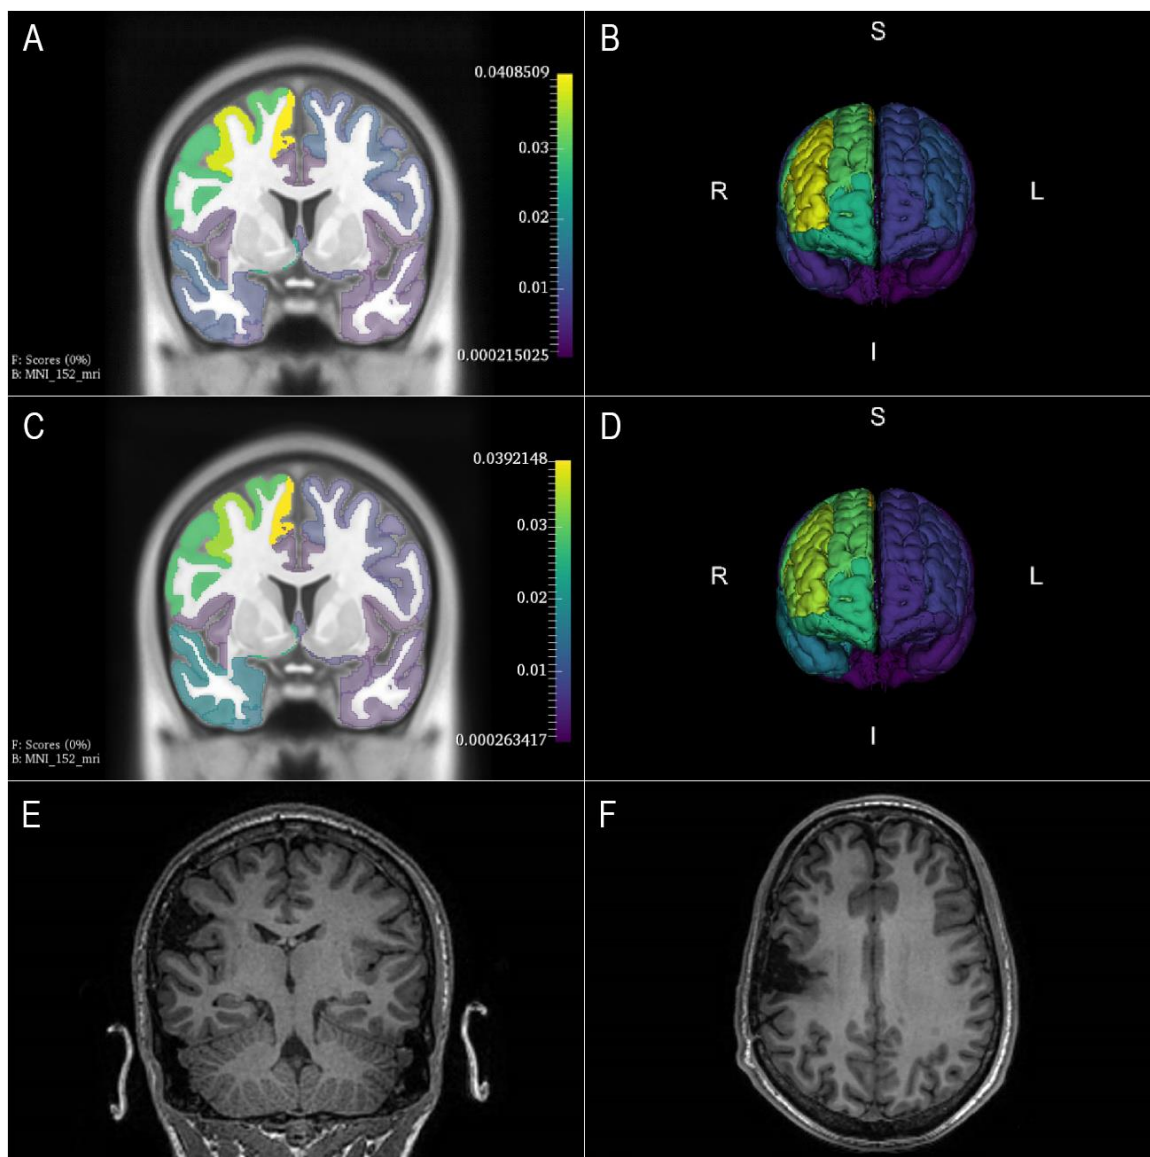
Example of Semiology Visualisation Tool. The top row demonstrates epileptogenic zone prediction using initial semiology in coronal (A) and 3D (B) views. The middle row demonstrates epileptogenic zone prediction using combined set-of-semiology in coronal (C) and 3D (D) views. The bottom row demonstrates the postoperative MRI in T1 coronal (E) and axial (F) views.
